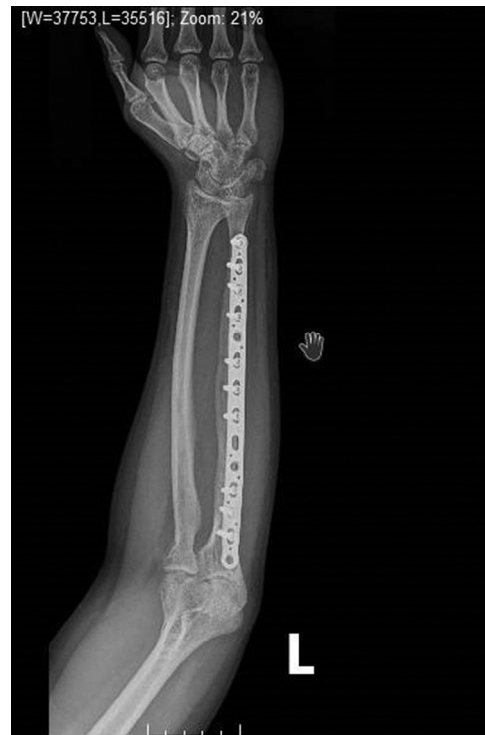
Anteroposterior radiograph demonstrating reduction of the radiocapitellar joint and union of the ulna segmental fracture at 6 months postoperatively.
